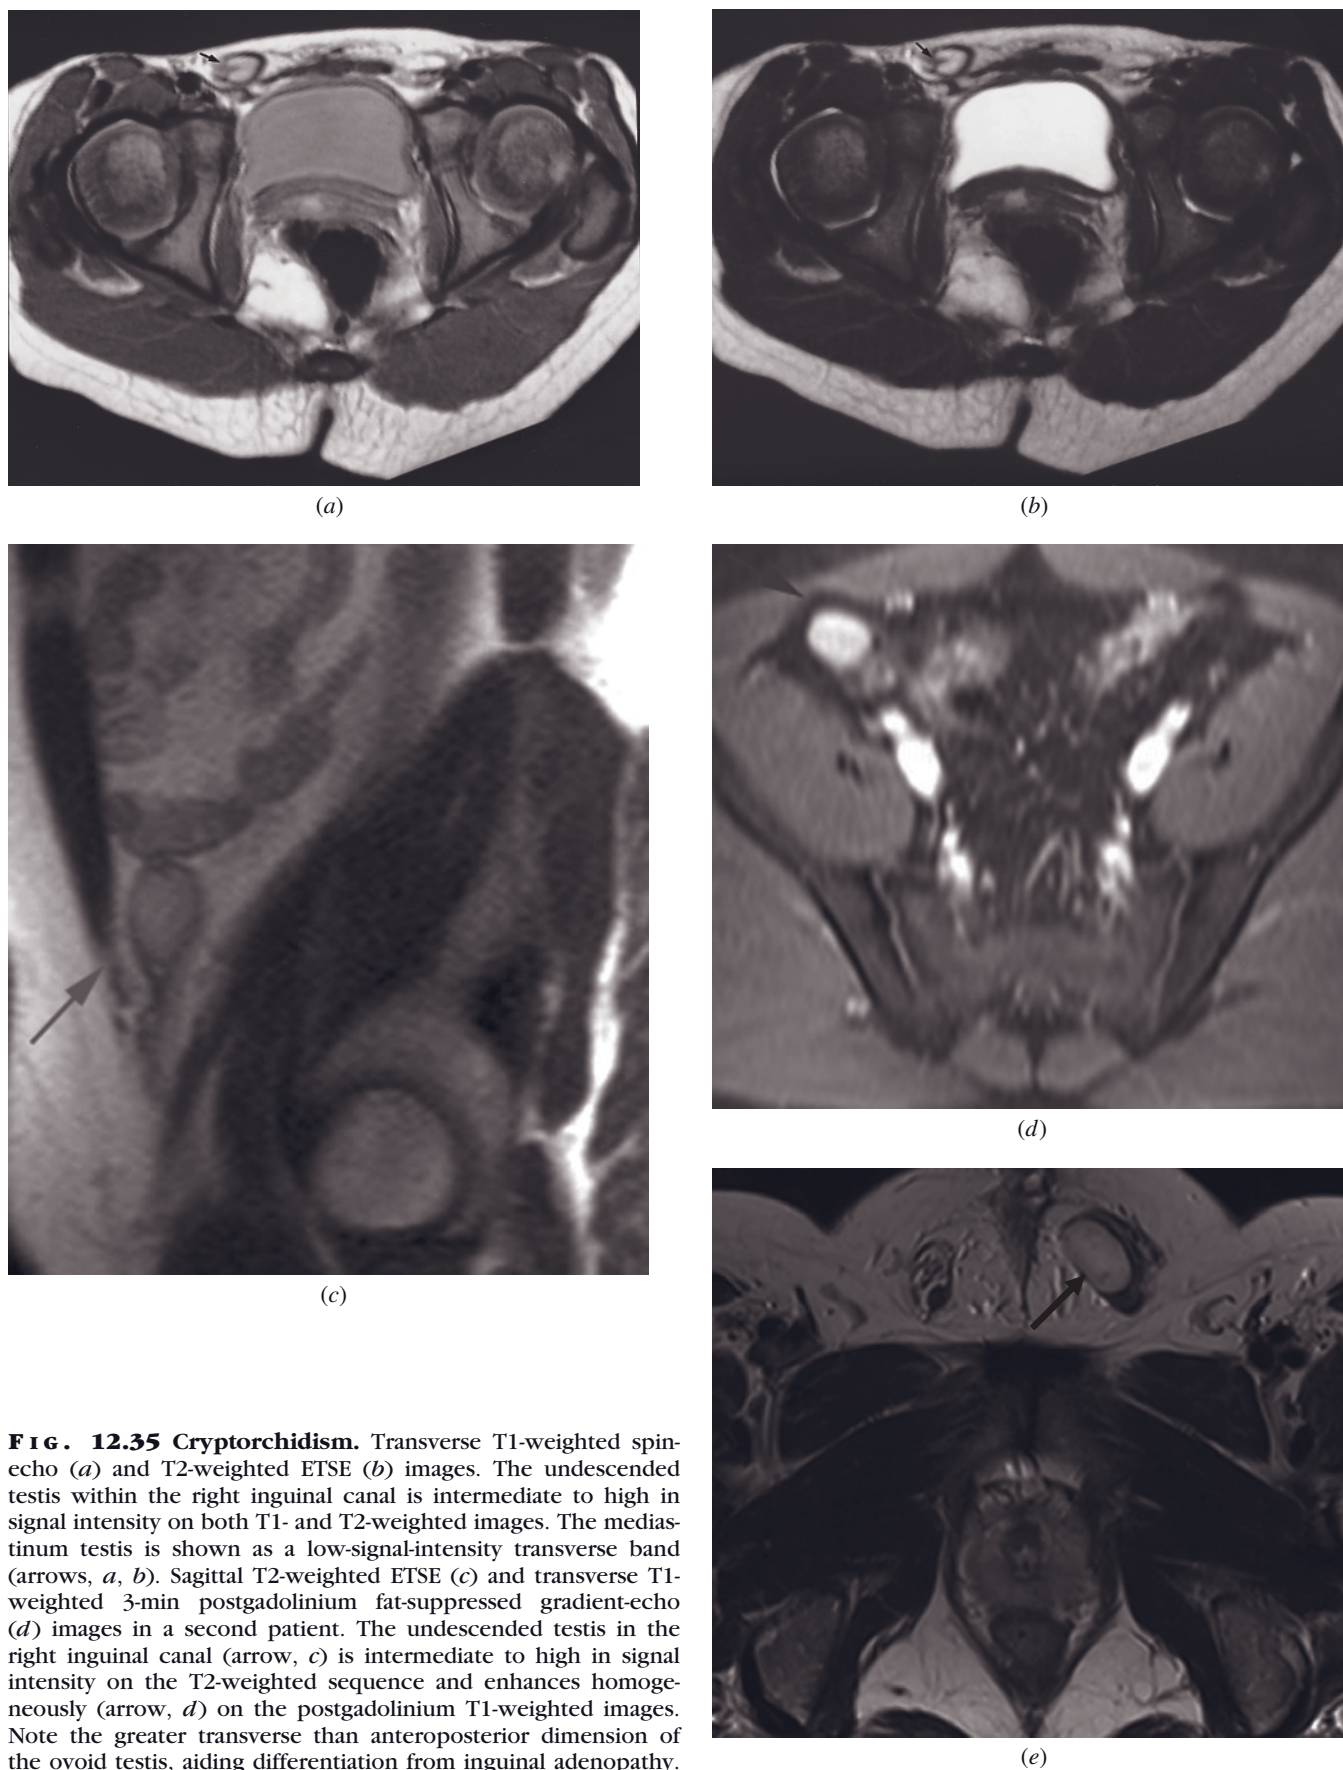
Cryptorchidism. Transverse T1-weighted spin-echo (a) and T2-weighted ETSE (b) images. The undescended testis within the right inguinal canal is intermediate to high in signal intensity on both T1- and T2-weighted images. The mediastinum testis is shown as a low-signal-intensity transverse band (arrows, a, b). Sagittal T2-weighted ETSE (c) and transverse T1-weighted 3-min postgadolinium fat-suppressed gradient-echo (d) images in a second patient. The undescended testis in the right inguinal canal (arrow, c) is intermediate to high in signal intensity on the T2-weighted sequence and enhances homogeneously (arrow, d) on the postgadolinium T1-weighted images. Note the greater transverse than anteroposterior dimension of the ovoid testis, aiding differentiation from inguinal adenopathy.
